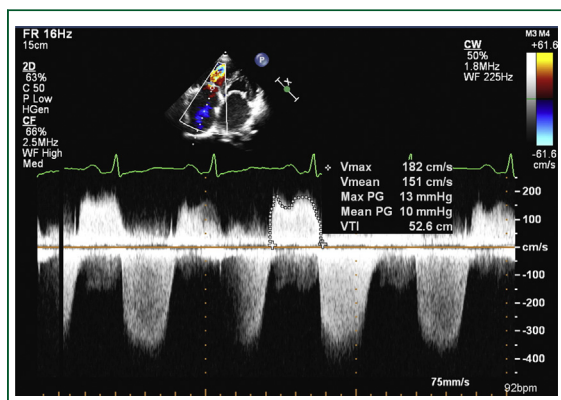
Doppler flow across tricuspid valve showing elevated mean gradient across tricuspid valve due to tricuspid stenosis.
